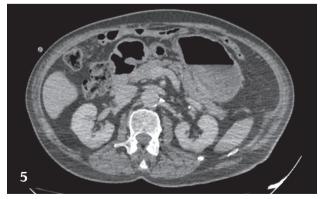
CTA: Axial image in the portal venous phase.
